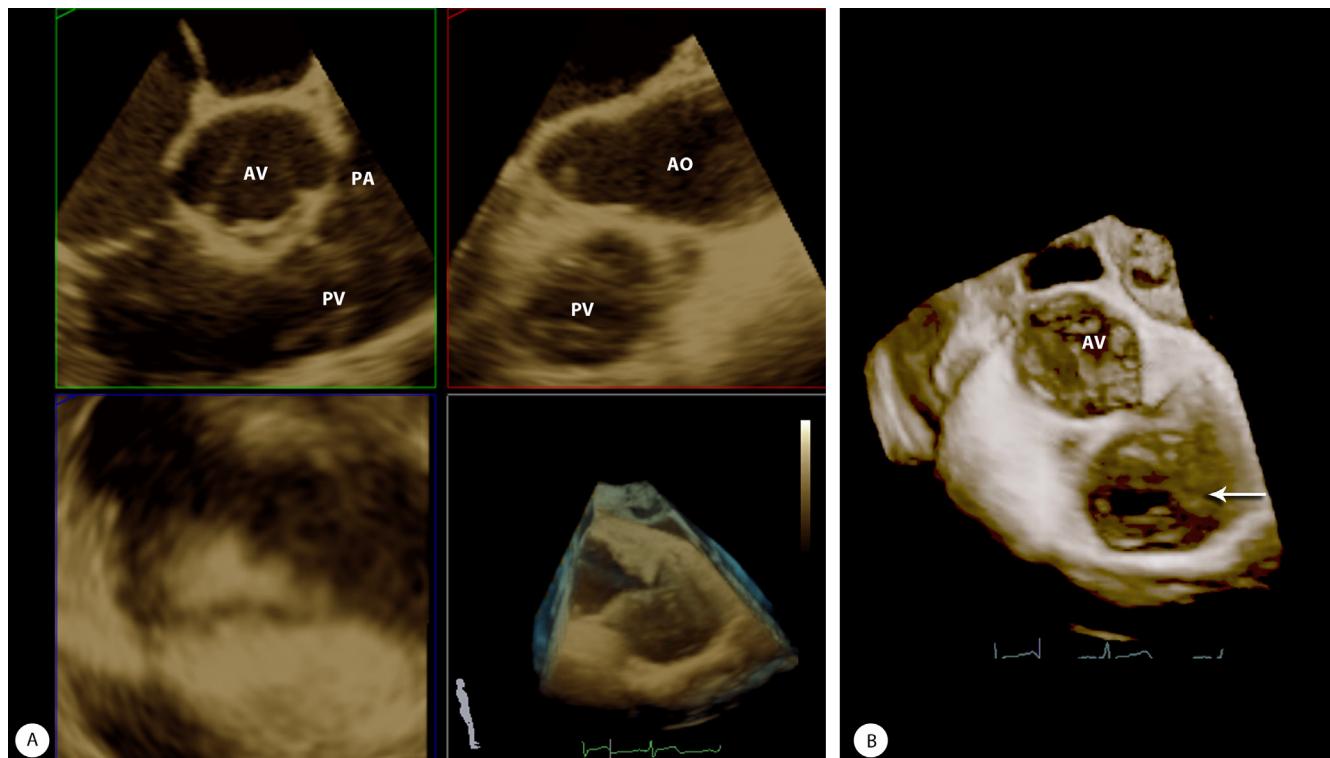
Transesophageal echocardiography with 3D imaging in (A) the multiplanar reconstruction mode demonstrates (B) the bicuspid pulmonic valve en face with doming and the poor coaptation of the PV leaflets (the arrow).
